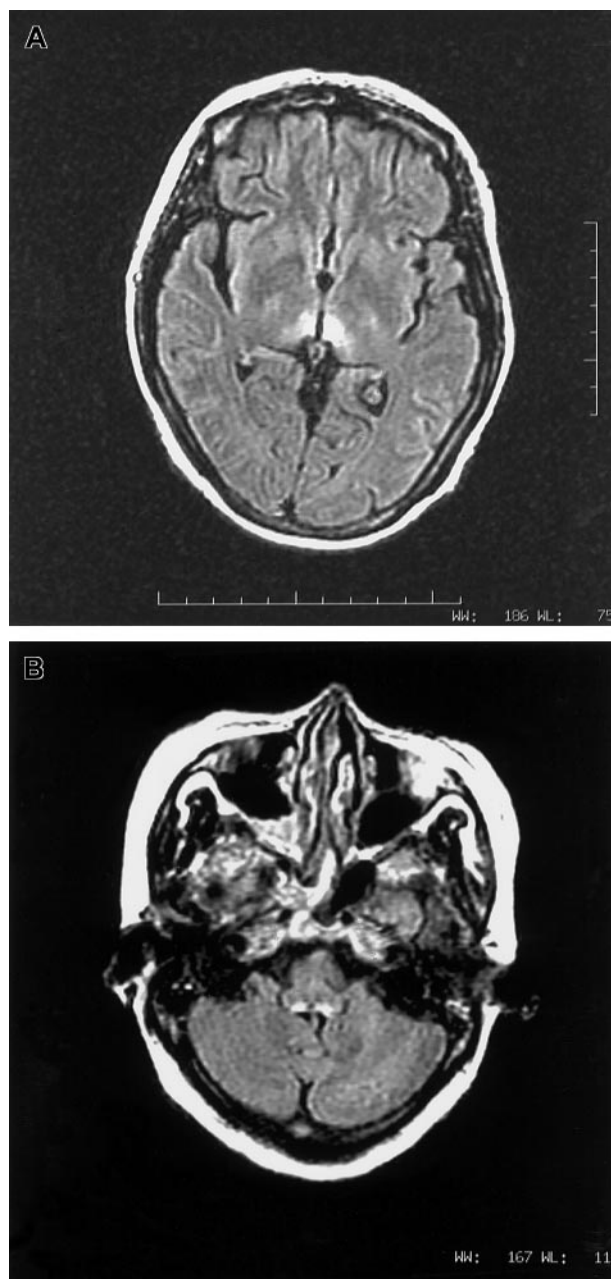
(A,B) MRI images in axial fluid attenuated inversion recovery sequence showing T2-weighted hyperintense lesions surrounding third ventricle (1A) and dorsal aspect of medulla (1B).
